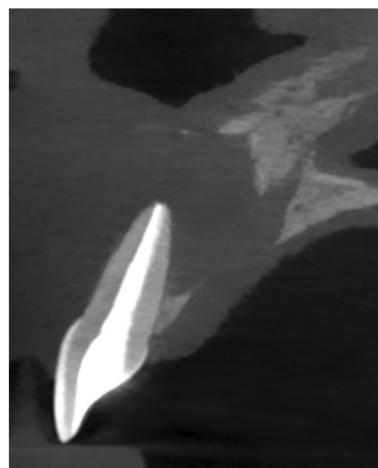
Sagittal slice of CBCT of Tooth #8 showing buccal and palatal cortical dehiscence prior to decompression.
